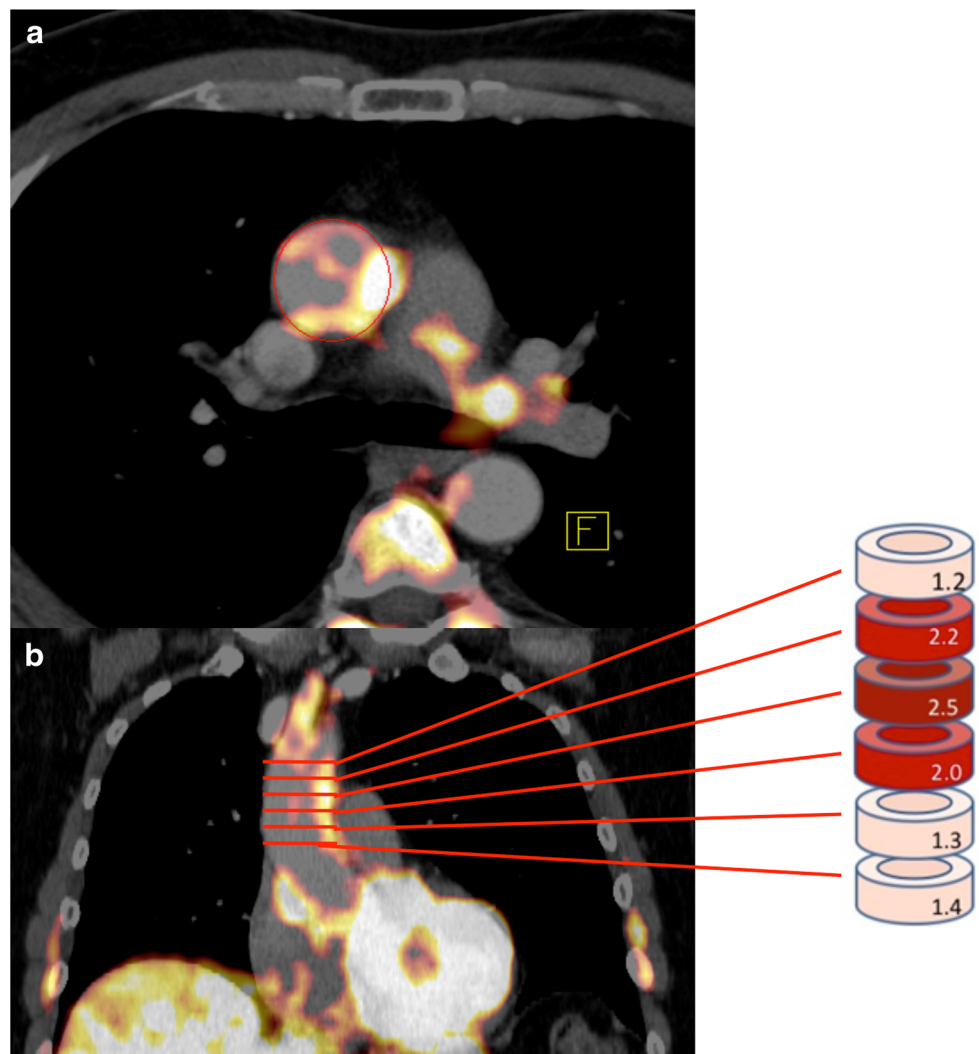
Study population enrollmentFig. 2 PET image analysis. SUV is measured in the wall of the ascending aorta in the axial plane (a) starting 1 cm above the origin of the coronary vessels and continuing to the bottom of the aortic arch in 5-mm increments (b). Arterial FDG uptake was recorded as the mean of maximum standardized uptake values (SUV_{max}) of all the slices
